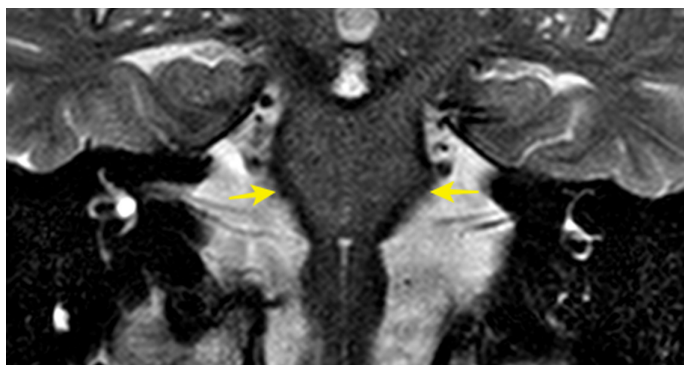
T2-weighted MRI images of patients with SS showing hemosiderin deposition (yellow arrows) along the brainstem at the CPA level in both axial (A) and coronal (B) views.
